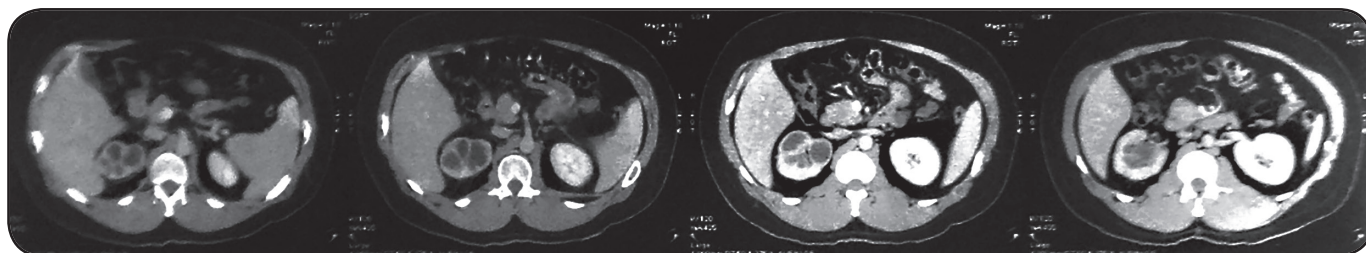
Abdominal computed tomography image showing pyelocaliceal dilation and thinning of the cortical region in the right kidney due to renal tuberculosis.
